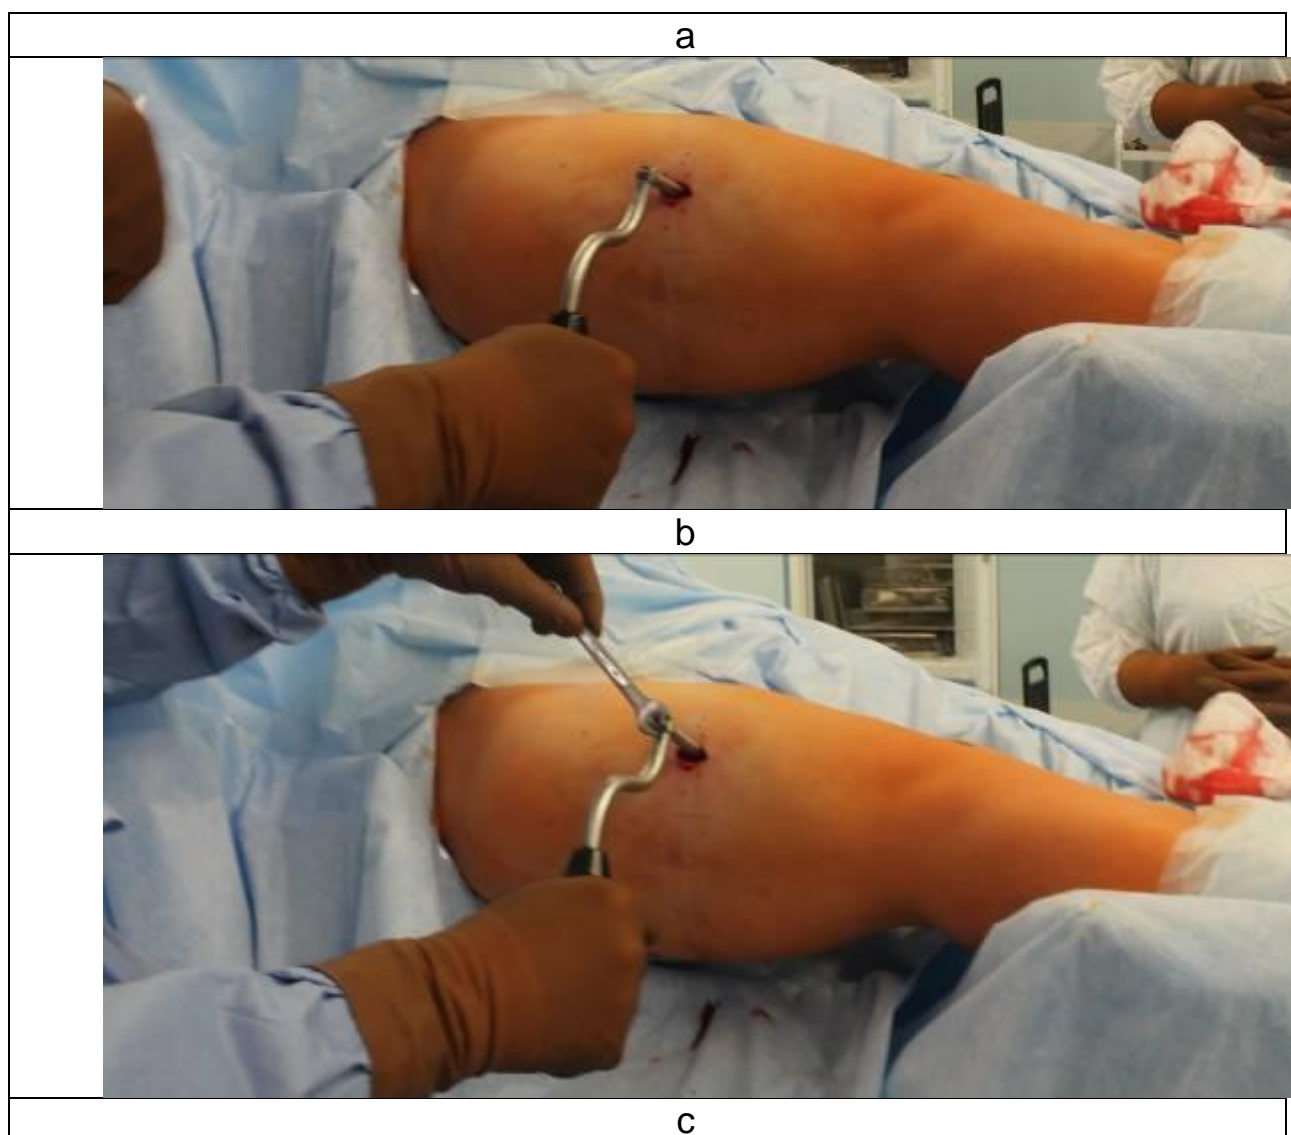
Removal of SUV-clamp: a, b – assembling of Instrument #1 on the shank of the hook-shaped part of SUV-clamp; c – fixation by a nut
